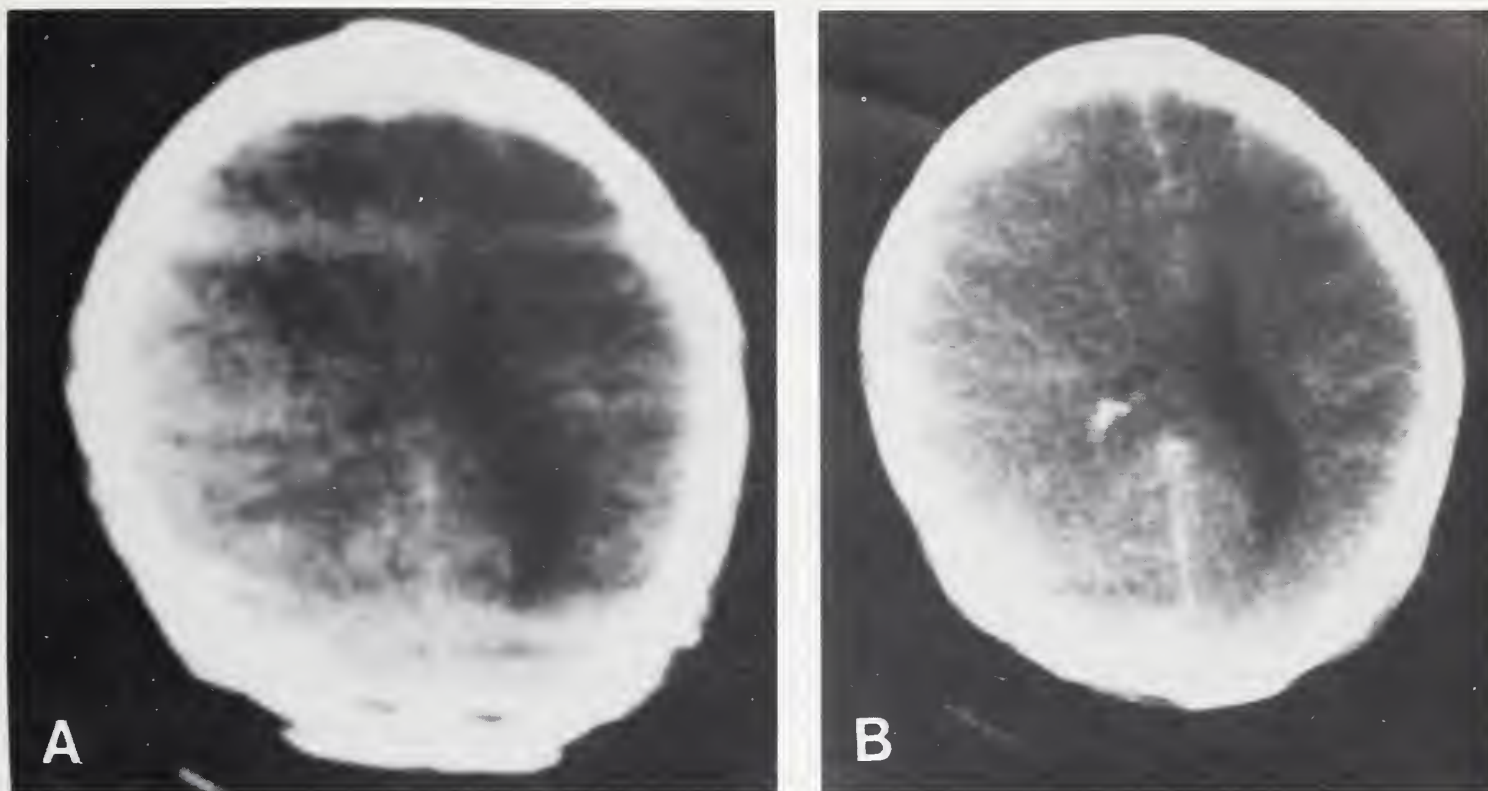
(A) Unenhanced computed tomographic (CT) scan demonstrating mass effect with obliteration of the right occipital horn and shift of midline structures from right to left. No extracerebral fluid collection was demonstrated. (B) Enhanced view with similar findings as in the unenhanced view except for better demonstration of the left ventricular system. Also noted was some contrast pooling in the area of the right occipital horn.
